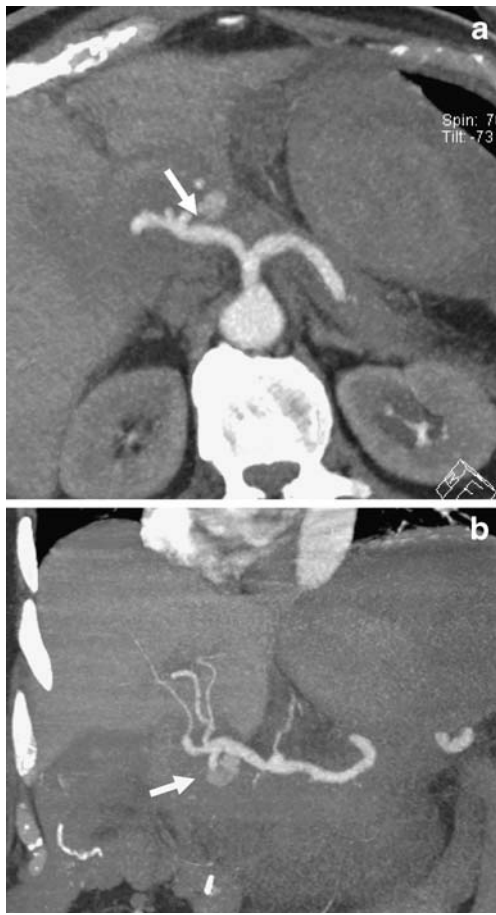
Contrast CT-scan performed on Patient 7. Pseudoaneurysm of the gastroduodenal artery (*arrow*) surrounded by hematoma. a Transverse plane, b coronal plane.
